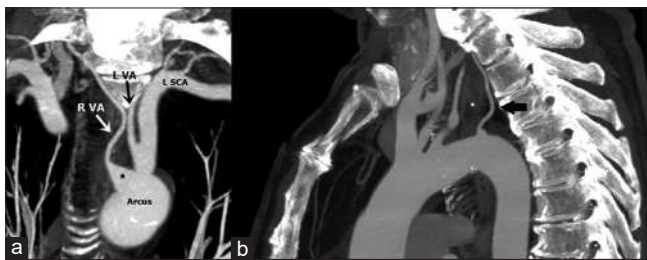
(a) The coronal CT maximum intensity projection image showed Kommerell's diverticulum (*) in the origin of the RVA and the extreme proximal origin of the LVA from the LSCA (arrow). (b) The sagittal maximum intensity projection CT image showed the retroesophageal course of the aberrant RVA. RVA: Right vertebral artery, LVA: Left vertebral artery, LSCA: Left subclavian artery, CT: Computed tomography
